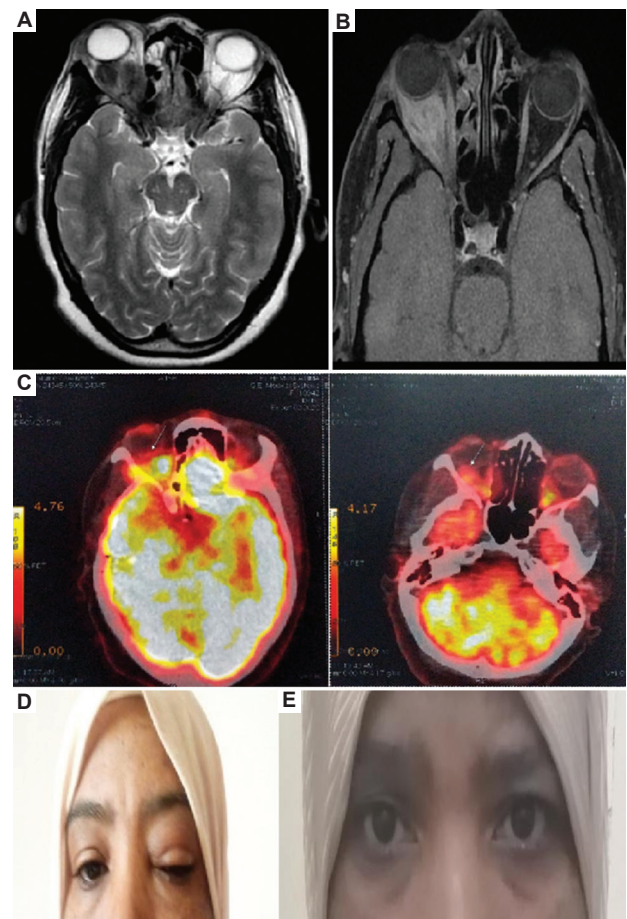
Medical examinations of Case 2. (A) Magnetic resonance imaging of the orbit. (B) Axial and coronal section in T2 sequence, demonstrating a T2-hyposignal, poorly defined right orbital intraconal infiltrate, not centered on a particular organ, and exhibiting weak enhancement after contrast administration, consistent with grade I exophthalmos. (C) Positron emission tomography scan obtained after 1 month of CD20 monoclonal antibodies (rituximab) treatment, demonstrating regression of metabolic activity. External photographs of the patient, captured before (D) and after (E) treatment.
